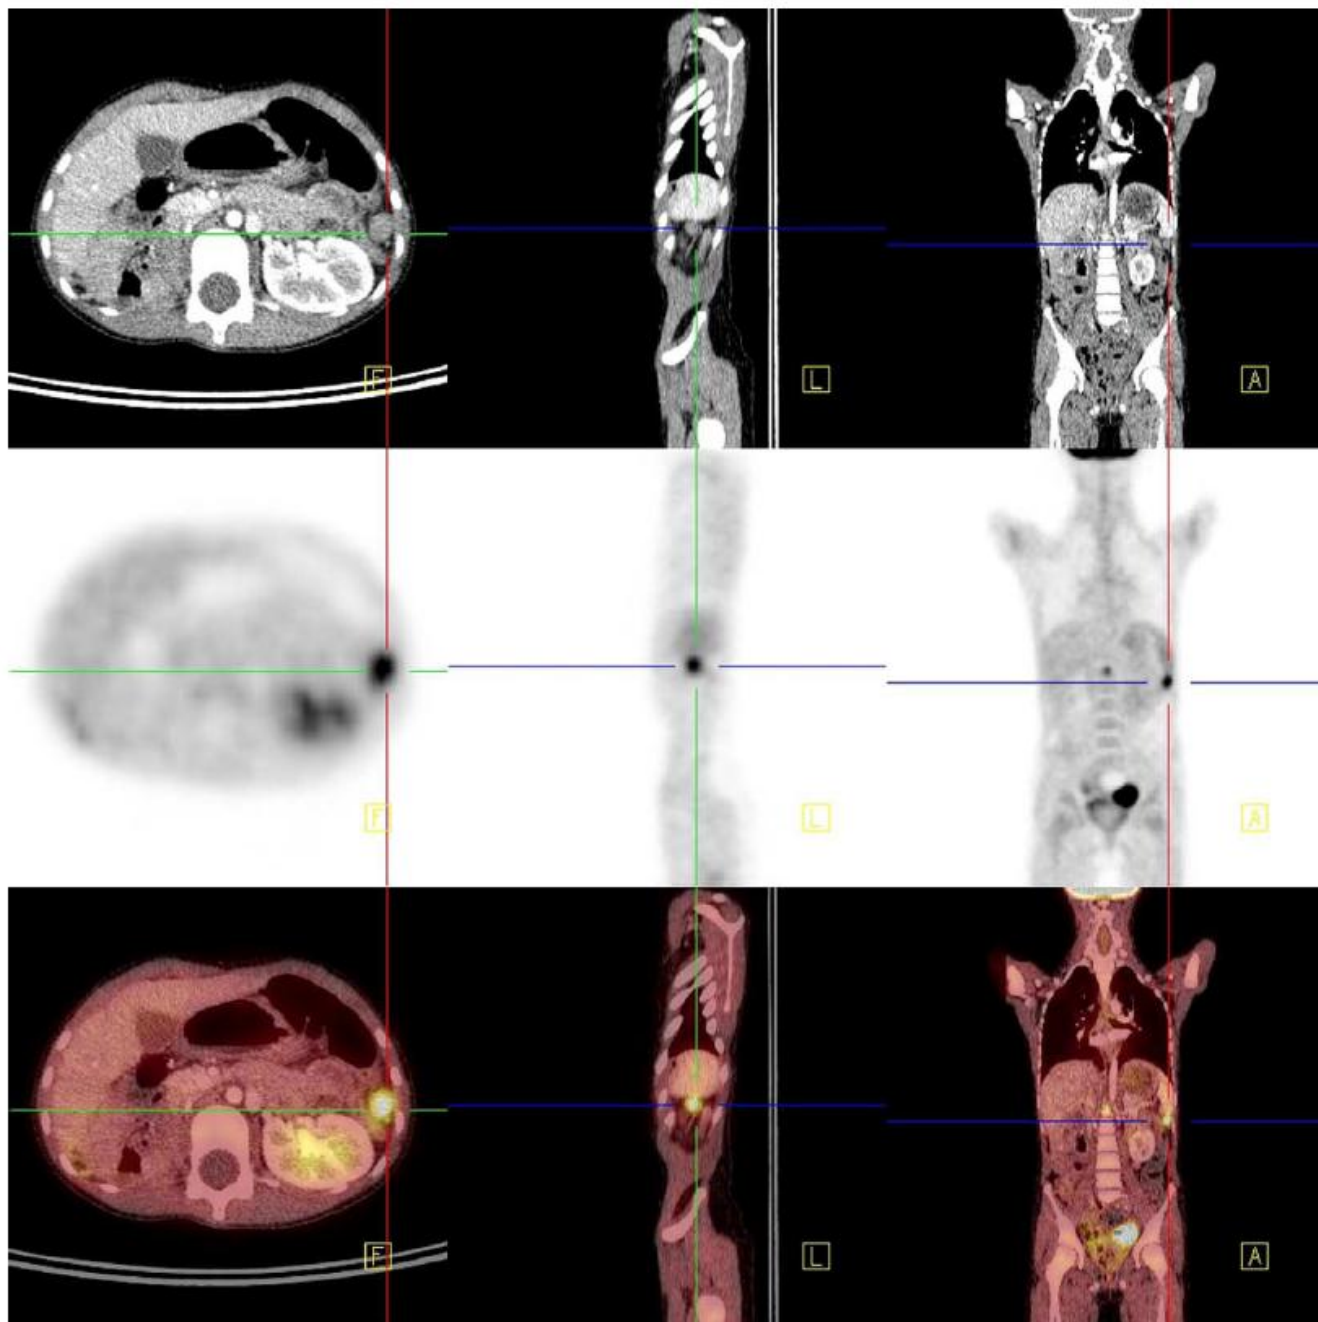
Recurrent anaplastic Wilms' tumor. Left upper quadrant omental tumor. Standard CT scan (top). PET scan (middle). PET/CT scan (bottom).
